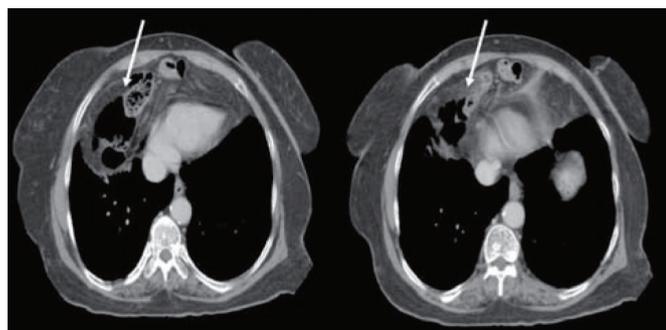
The abdominal CT revealing omental and intestinal structure in the right sided (white arrows) retrosternal Morgagni's Hernia in Case 1.
